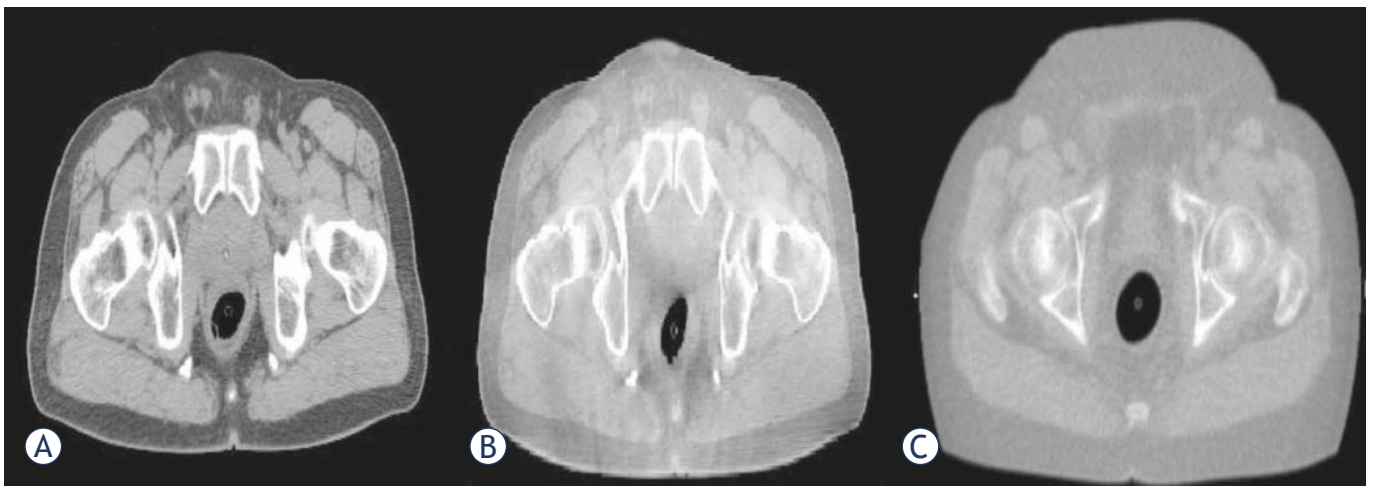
(A) kVCT, (B) kV CBCT and (C) MVCT images in transverse view are represented. As seen in figure the soft tissues contrast is better for kV CBCT images in comparison to MVCT image.
